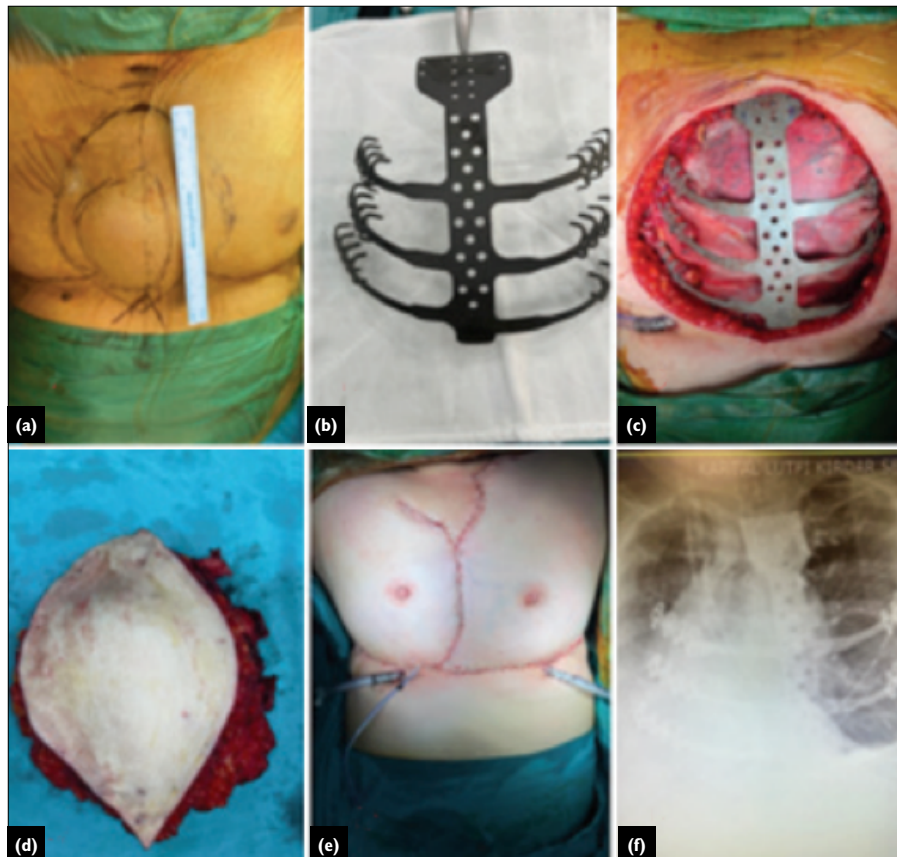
(a) Preoperative appearance of sternum with tumor, (b) Custom-made 3D material, (c) Peroperative view, (d) Resected material, (e) Postoperative view, (f) Postoperative X-ray.
